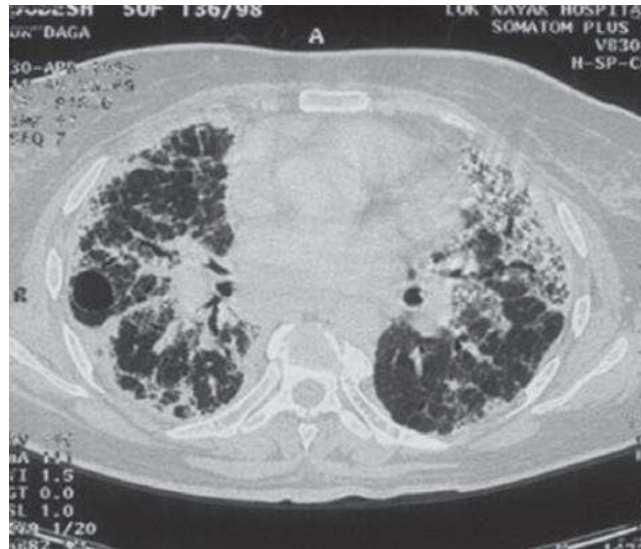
CT image of fibrosis [15].
